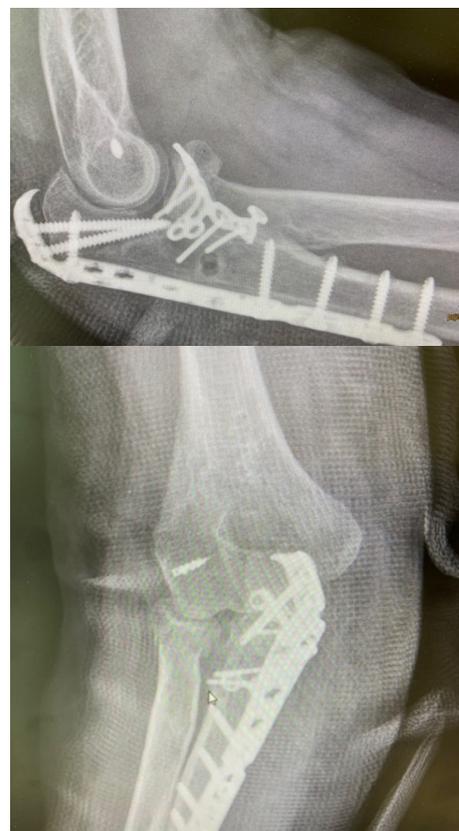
Postoperative X-rays showing good reduction of the coronoid fragment and joint congruency without signs of instability.
